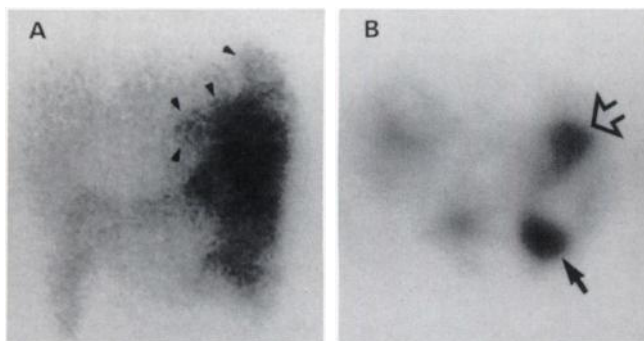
Planar scintigram (A) of the abdomen shows substantial and ill-defined radiogallium accumulation in the left upper quadrant. Small arrowheads indicate the probable location of the stomach. (B) A selected transaxial SPECT view serves to clarify the planar image. The open arrow identifies the stomach and a solid arrow shows the colon. Such cases require careful evaluation of projections in all three planes.
